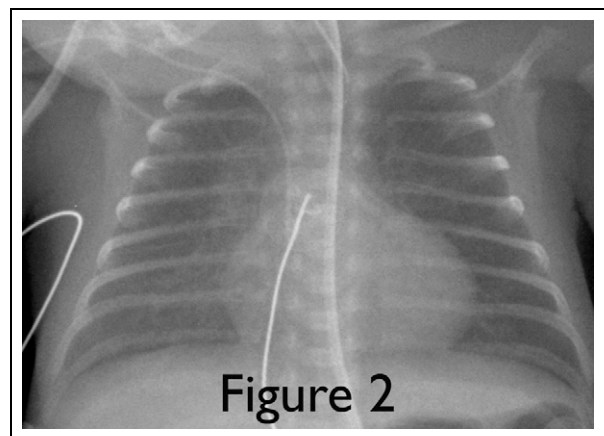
Chest radiograph of an infant with new bronchopulmonary dysplasia. The lungs have diffuse haziness. Note the surgical clip from patent ductus arteriosus ligation.
